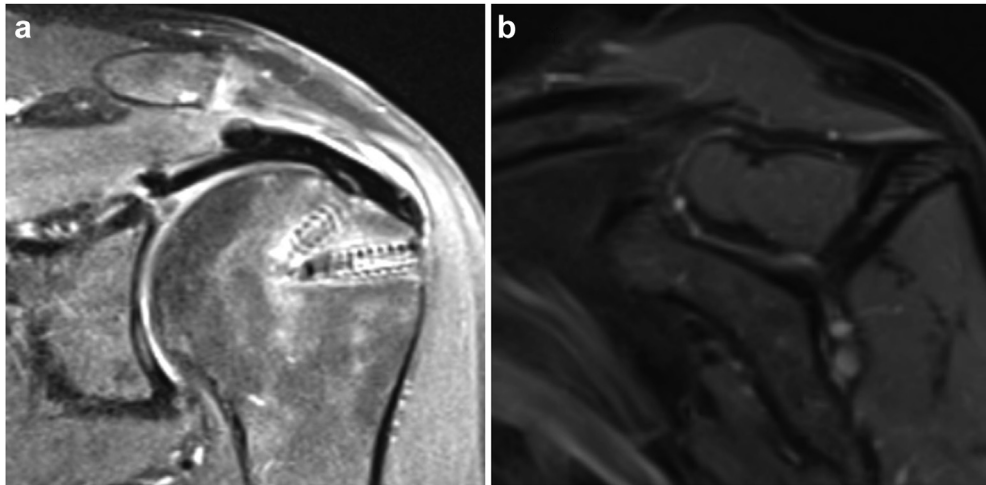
(a) Postoperative coronal T1 and (b) sagittal T2 MRI at 15 months showing intact superior capsule and rotator cuff grafts and Goutallier stage 0/1 supraspinatus. MRI, magnetic resonance imaging.
